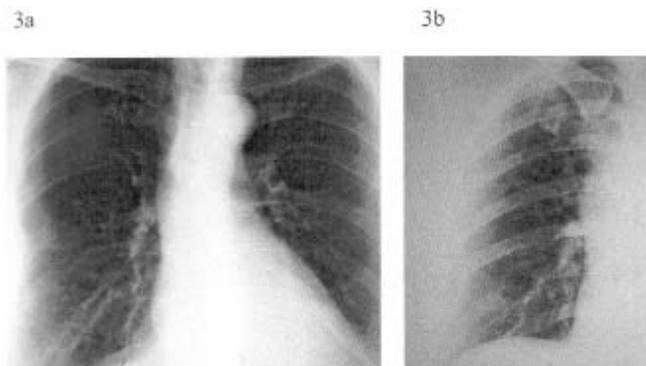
Show photographs of a PA chest X-ray and an oblique view of the right hemithorax, showing the condition following open biopsy of the 8th right rib which was performed 5 years previously and radiological resolution of other rib lesions (decrease in the size of the radiolucent areas).
